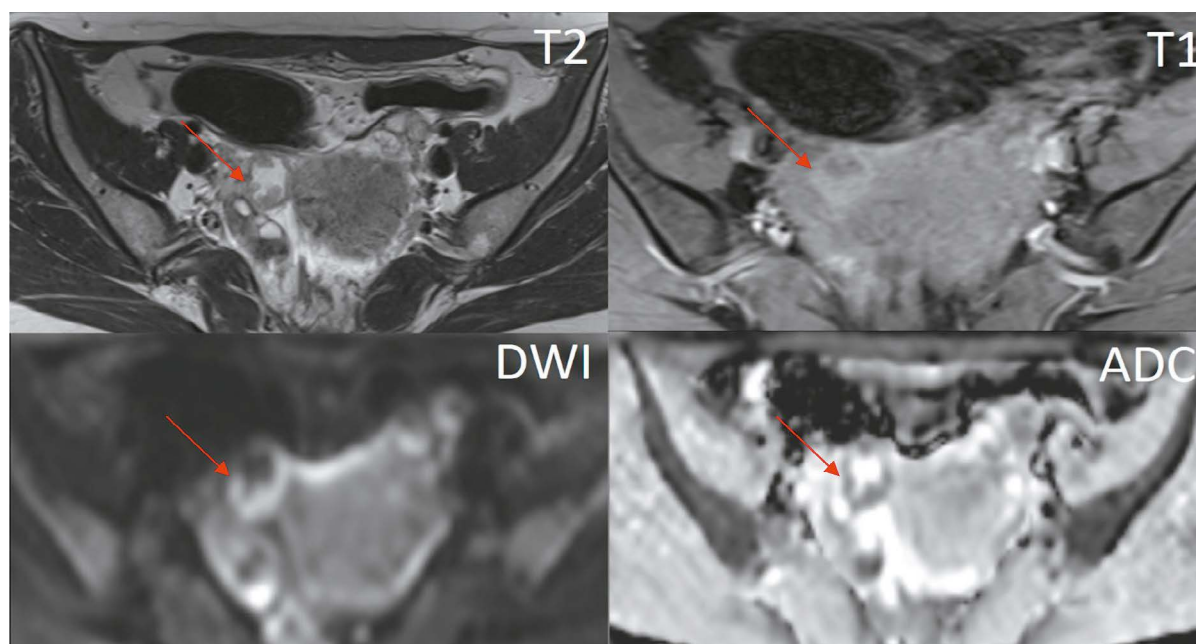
Pelvic magnetic resonance imaging (axial view). The right fallopian tube contains fluid and solid nodules, with signs of restricted diffusion on DWI mode (red arrow).
